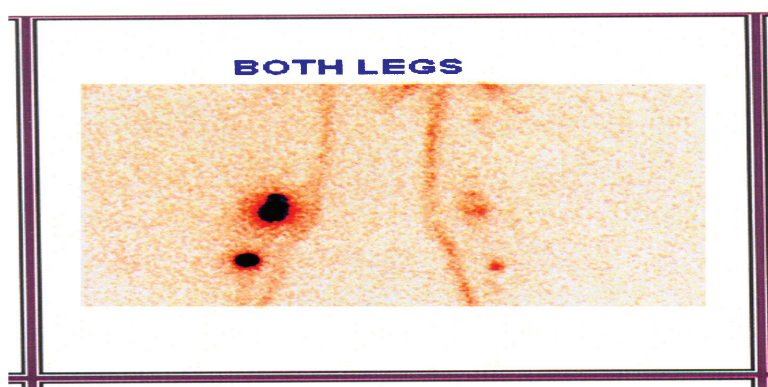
Lymphoscintigraphy in an asymptomatic children showing less lymphatic flow on right leg with right popliteal node enlargement.
